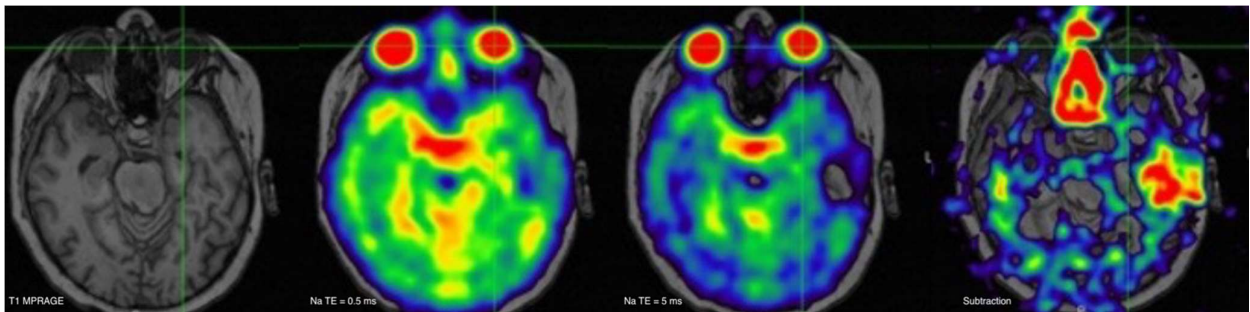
Dual-TE  $^{23}\text{Na}$ -MRI in a pediatric patient with suppression of the elevated “free” sodium signal within vitreous fluid of the globe (crosshair). Note  $T_2$  based signal loss from  $TE = 0.5$  to  $5$  ms. Also note, susceptibility artifact in the left temporal lobe and nasal cavity, becoming especially pronounced on subtraction. (Same patient in figures 3-6)
